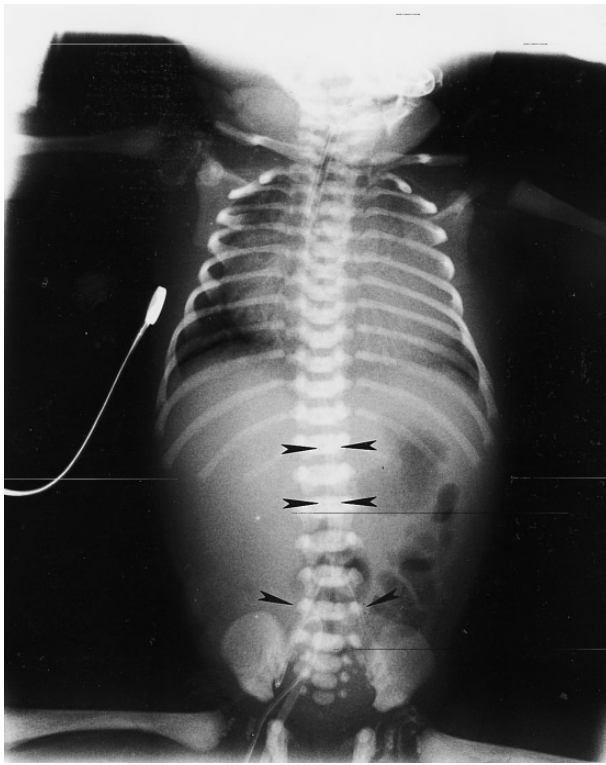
Radiograph of the thorax and abdomen at birth, showing a double line of calcification on the distal aorta and iliac bifurcation (arrowheads).
